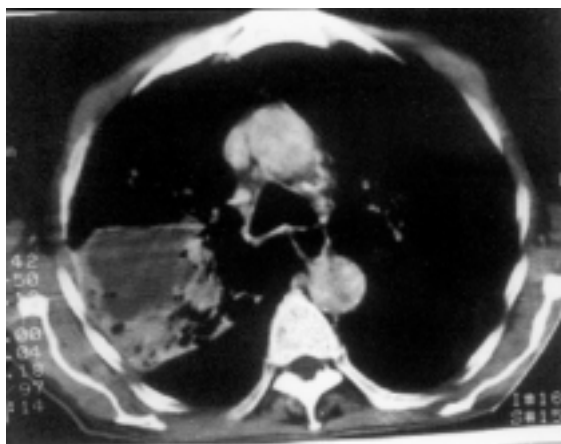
CT scan chest; peripheral bronchogenic carcinoma with central necrosis and chest wall invasion.
